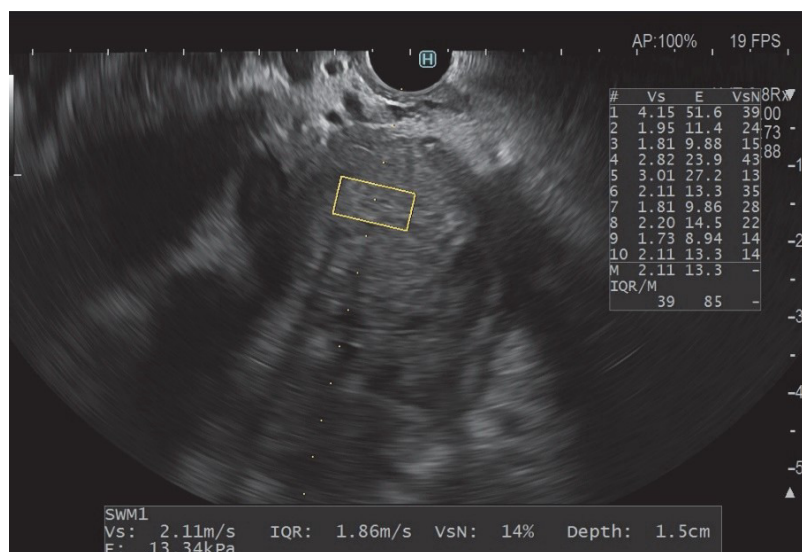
Shear-Wave Type Endoscopic Ultrasound Elastography
